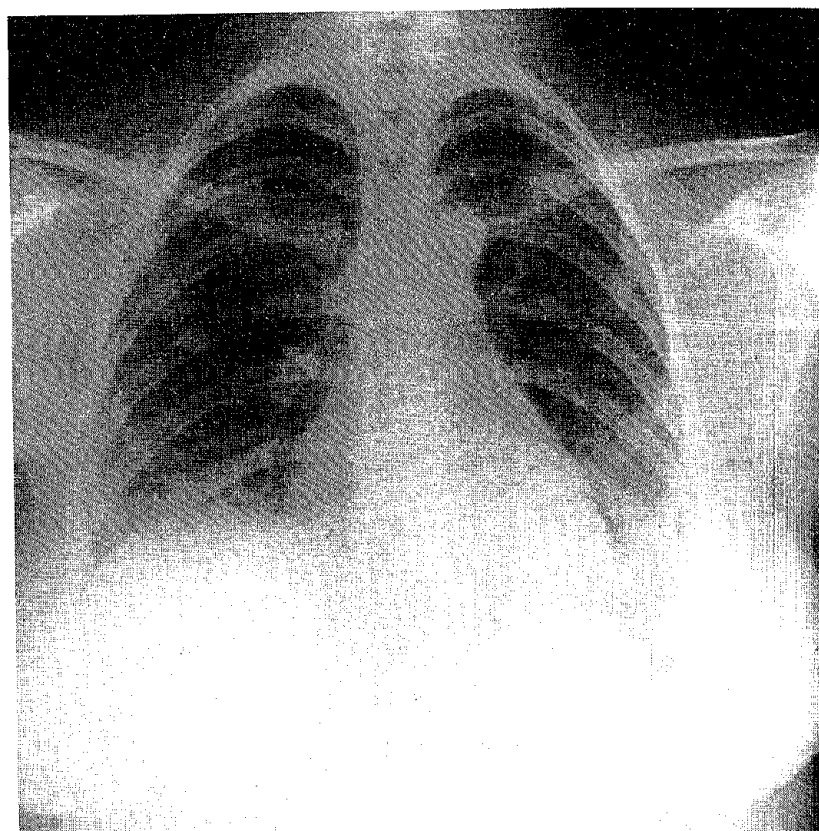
Incorrect position, posteroanterior chest radiograph, lungs in expiration.
